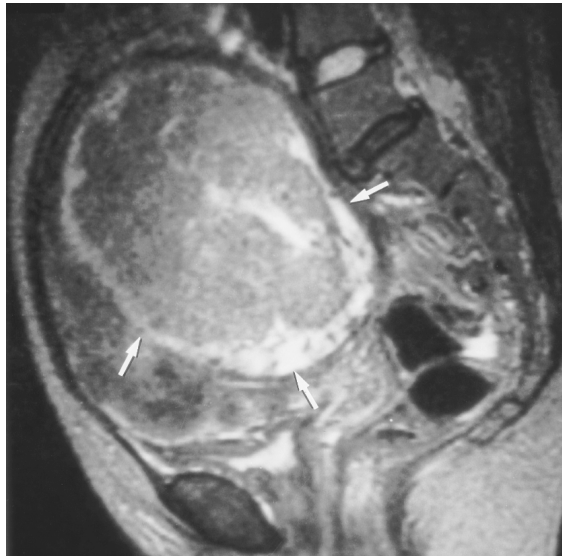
Red degeneration in a 44-year-old woman with sudden onset of abdominal pain. (a) Sagittal fast spin-echo T2-weighted MR image (5,000/100) obtained several hours after onset shows a thick rim of distinct low signal intensity that corresponds to acute hemorrhage (arrows). (b) Sagittal spin-echo T1-weighted MR image (600/13) obtained several hours after onset shows no significant findings. (c) Sagittal gadolinium-enhanced spin-echo T1-weighted MR image (600/13) obtained several hours after onset shows complete absence of enhancement, a finding that indicates infarction.
